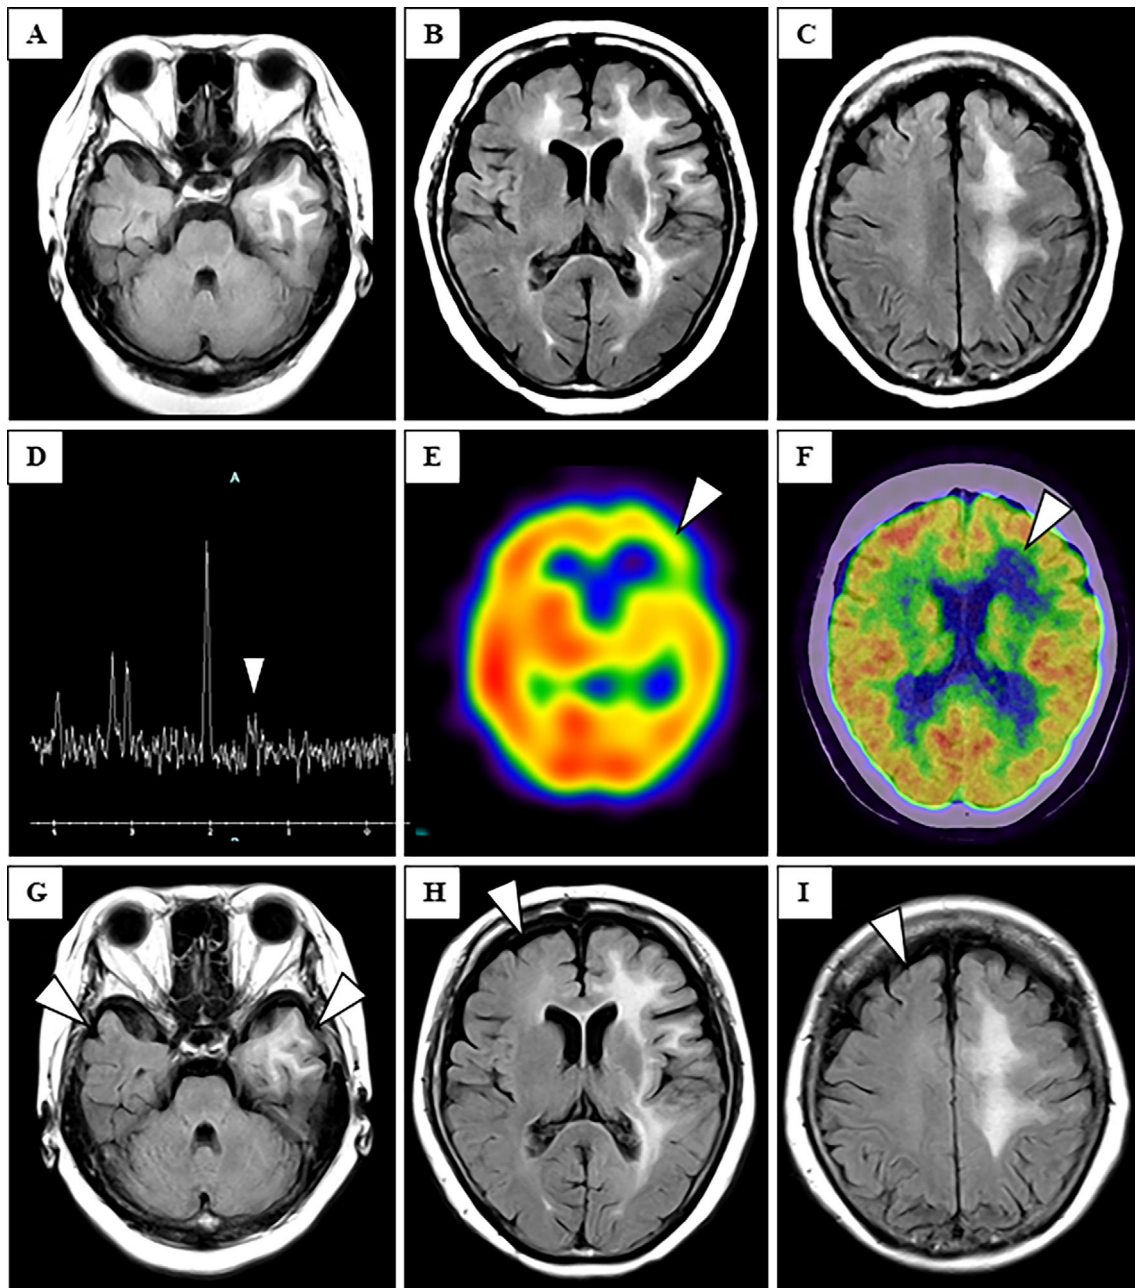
A brain MRI showed leukoencephalopathy in the bilateral temporal, frontal, and parietal lobes (A-C) with a lactic acid peak in MRS (D, arrowhead), a decreased blood flow in SPECT (E, arrowhead) and a decreased accumulation in FDG-PET (F, arrowhead). The brain MRI findings improved at 3 months after TCZ discontinuation (G-I, arrowheads).
